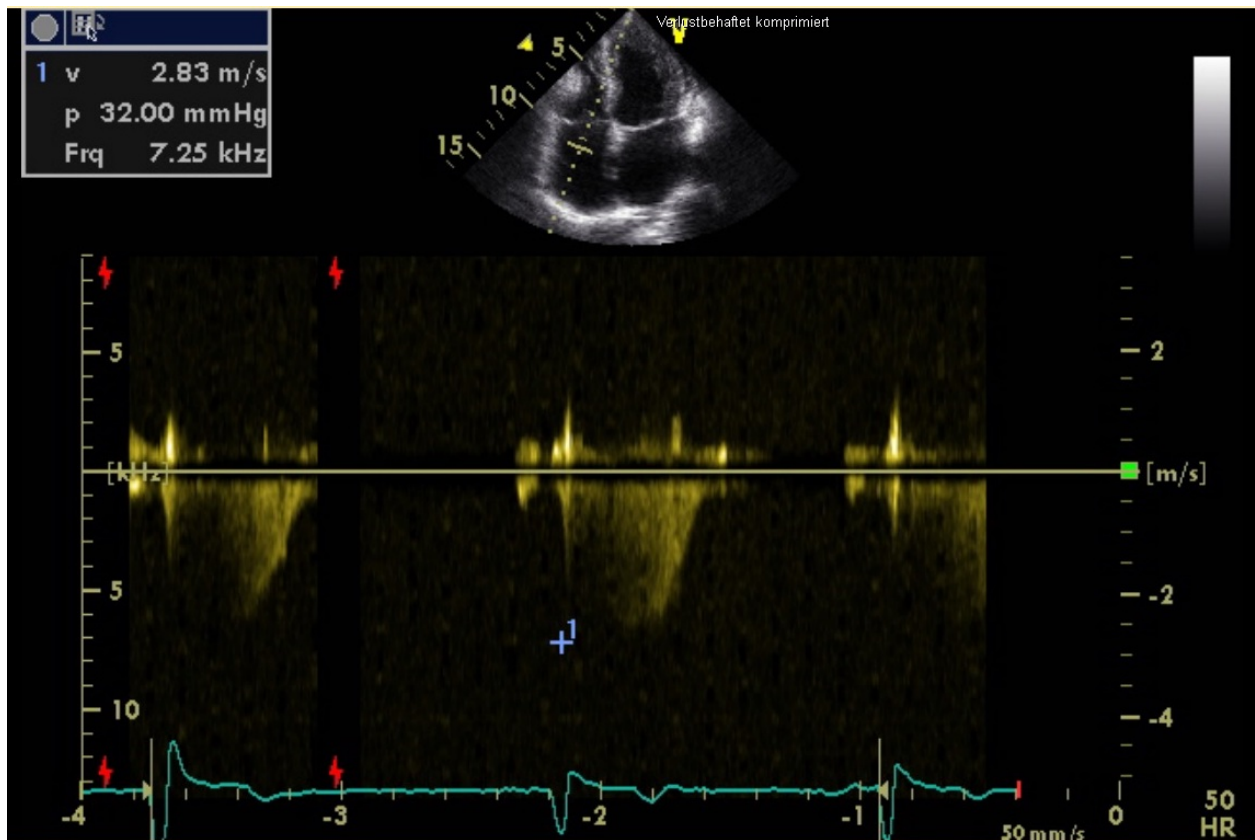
original echocardiographic image made in this study demonstrating how the TR Vmax was determined.
